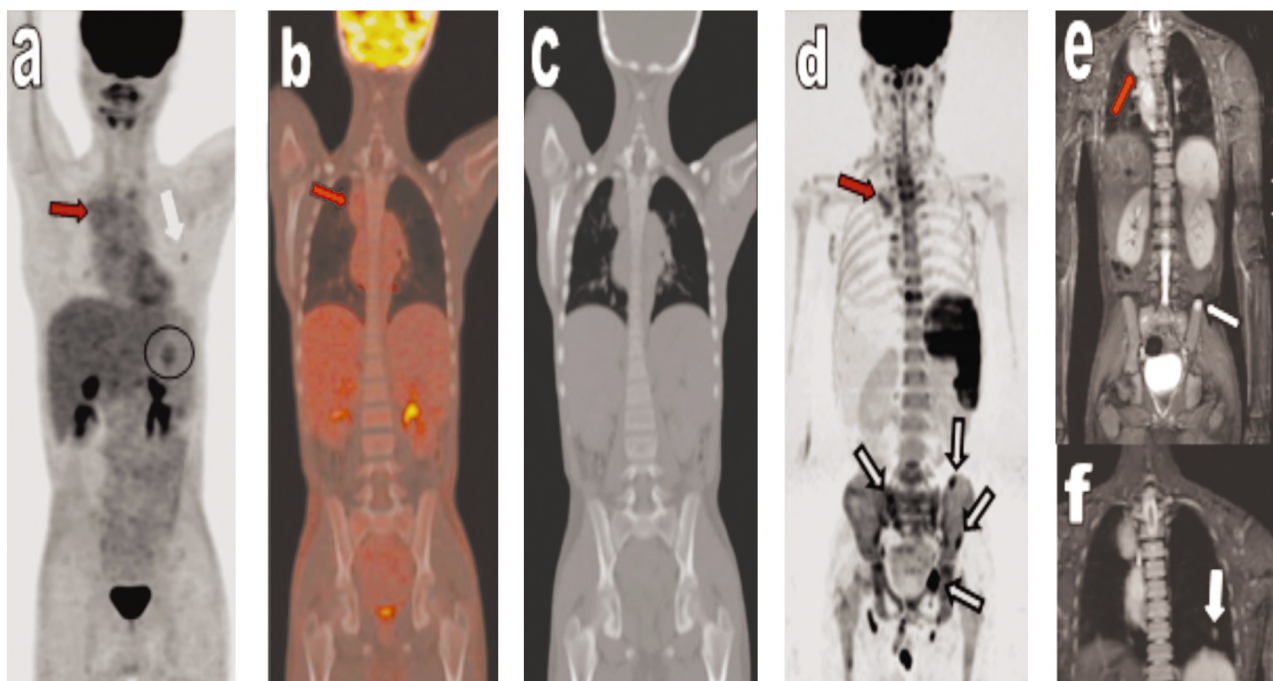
PET-CT versus WB-DWIBS in a 15 years old male. (A): MIP-PET image (B): Fused coronal PET-CT images (C): coronal CT bone window image (D): Inverted grey scale MIP WB-DWIBS image. (E,F): Coronal WB-STIR images. Both PET-CT and DWIBS demonstrated positive mediastinal nodal (red arrows) and pulmonary involvement (white arrows). Multiple pelvic and vertebral osseous lesions seen at DWIBS images (open arrows), not seen in the corresponding sites at PET-CT images. Splenic involvement was diagnosed by PET-CT due to presence of metabolically active (FDG avid) focal splenic lesion (circle) and diagnosed by DWIBS due to presence of splenomegaly.
